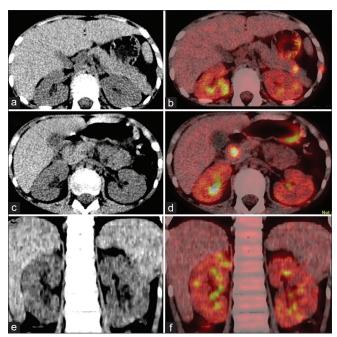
(a) Axial computed tomography abdomen image showing a hypodense lesion in the tail of pancreas showing intense fluorodeoxyglucose uptake in the fused positron emission tomography-computed tomography image (b). (c) Axial computed tomography abdomen image showing a hypodense lesion in the head of the pancreas showing intense fluorodeoxyglucose uptake in the fused positron emission tomography-computed tomography image (d). (e) Coronal computed tomography image showing bilateral enlarged kidneys showing increased fluorodeoxyglucose uptake (>liver) in the fused positron emission tomography-computed tomography image (f)
